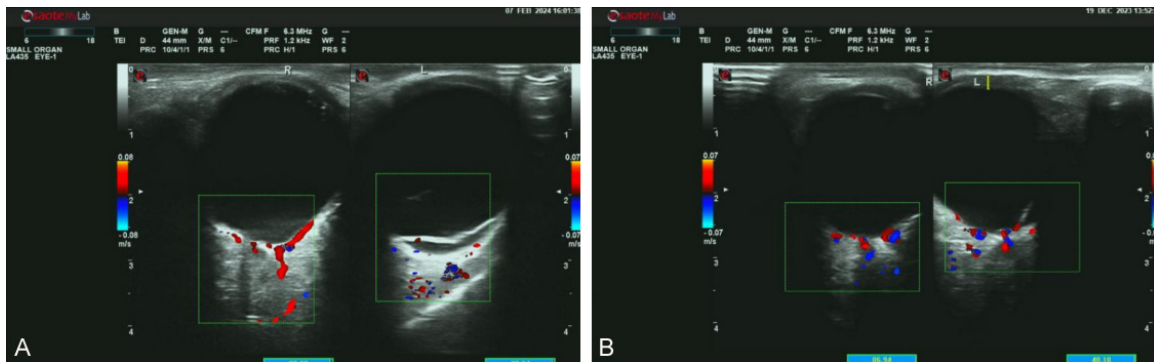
Typical fundus B-ultrasound image. A. Weak echoes and striated and banded echoes are captured in the vitreous cavity of the left eye, and the banded echoes are connected to the optic disc and temporal bulbar wall echoes; B. A strong intravitreal band echo is captured in the left eye, which is connected to the optic disc echo, and a blood flow signal is seen on color Doppler flow imaging.
